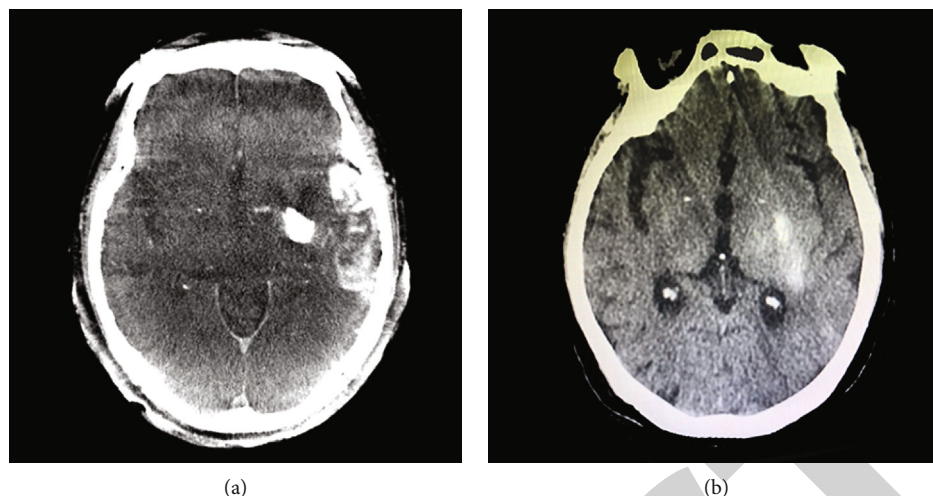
Images of post-procedure flat-panel CT (a) and non-contrast CT (b) in one patient. Flat panel CT shows hyperdensity in the left basal ganglia and left temporosphenoid lobe. The  $HU_{max}$  of left basal ganglia is 1405 and the  $HU_{max}$  of left temporosphenoid lobe is 474. Noncontrast CT revealed hemorrhage only in the left basal ganglia.
